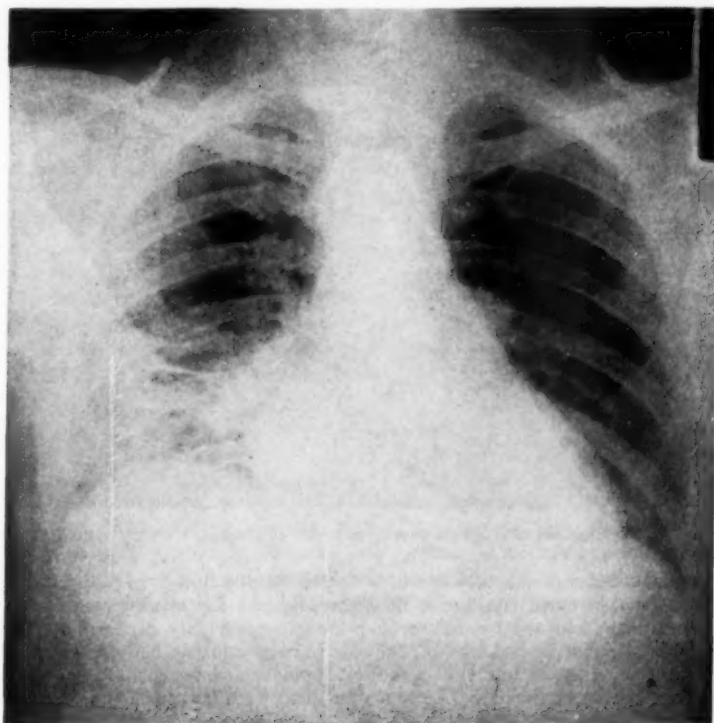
Roentgenogram of chest on admission (eighth day of disease), showing pulmonary congestion, infiltration and enlarged cardiac silhouette.
